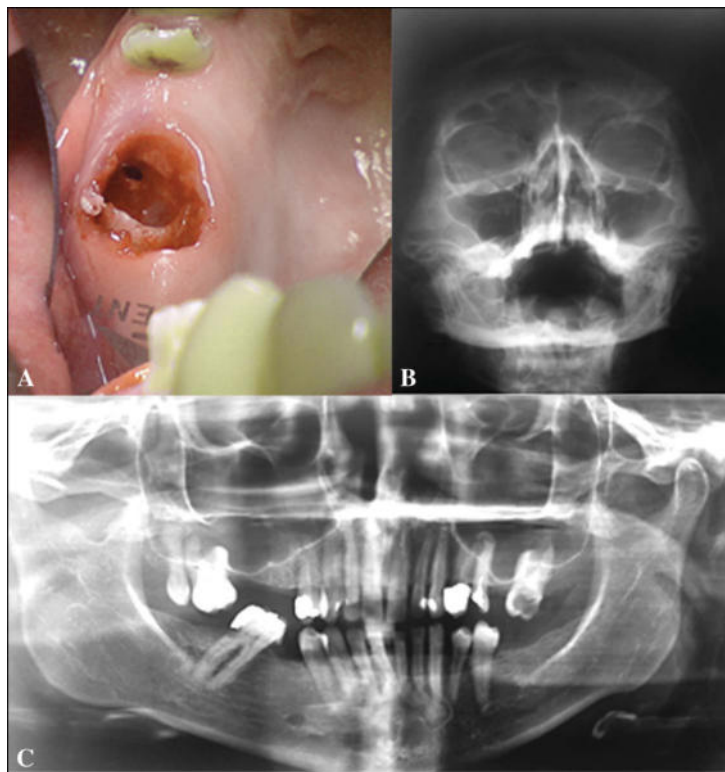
A, Intraoral appearance of OAC (mirror images) at the site of the extracted tooth 27; B, Water's view radiography shows discreet left pathoses of the left maxillary sinus; C, panoramic radiography shows a nonvital second upper molar tooth before the exodontia.
